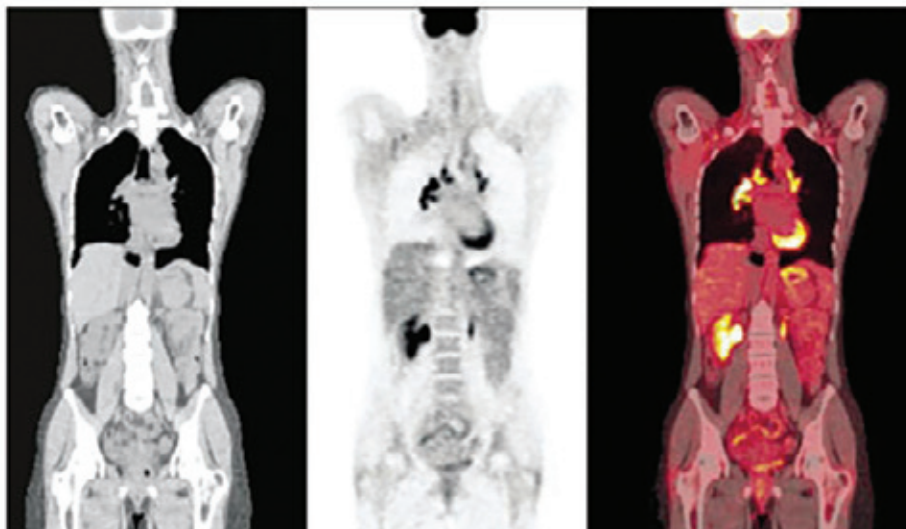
This shows a normal CT, PET and fused images (PET-CT) with the normal distribution of cellular activity.
